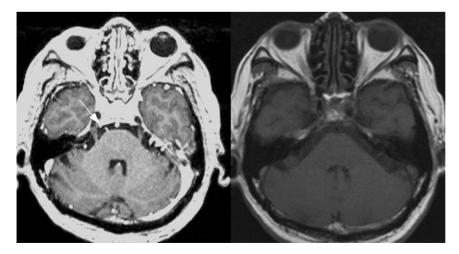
MRI scans of the axial section of the patient's brain. Magnetisation-prepared rapid gradient echo images (left) show the enhancement of right sixth nerve (arrow). An unmodified plain T1 image is also shown (right).
